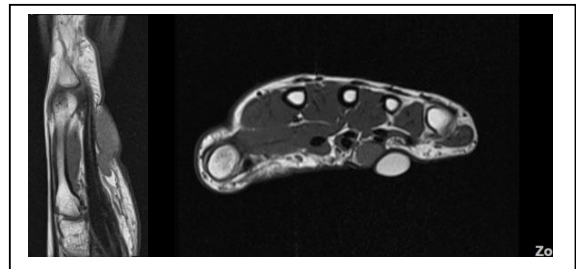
MRI of right hand in saggital (left) and coronal view (right).
